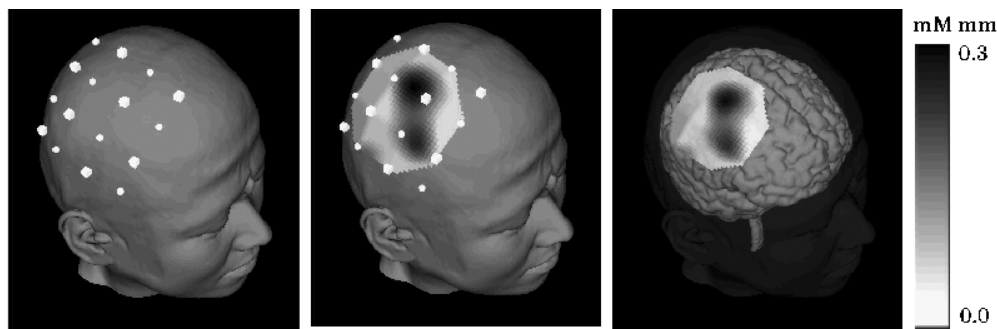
An optical topography image obtained using the Hitachi ETG-100 system showing [HbO] during a motor task mapped onto the MR image of a normal volunteer. Activation is seen in the right motor cortex following gripping of the left hand (reprinted from Kawasaki *et al* (2002), with permission from Elsevier).
